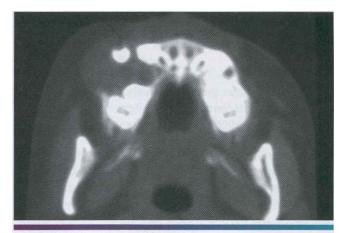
Embryonal rhabdomyosarcoma. CT scan of patient from Figure 12-135 showing expansile lytic lesion of the maxilla. (Courtesy of Dr. Robert Achterberg.)
